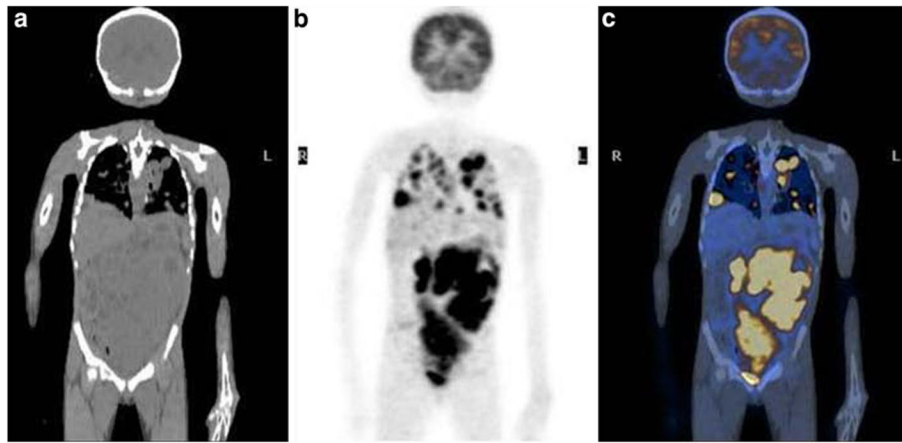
Patient 16: 7-year-old girl with newly diagnosed right-sided Wilms' tumor showing extensive metastatic disease in the chest, abdomen, and pelvis. a Noncontrast coronal CT image of the abdomen. b FDG PET at same level as a. c Fusion image of a and b
